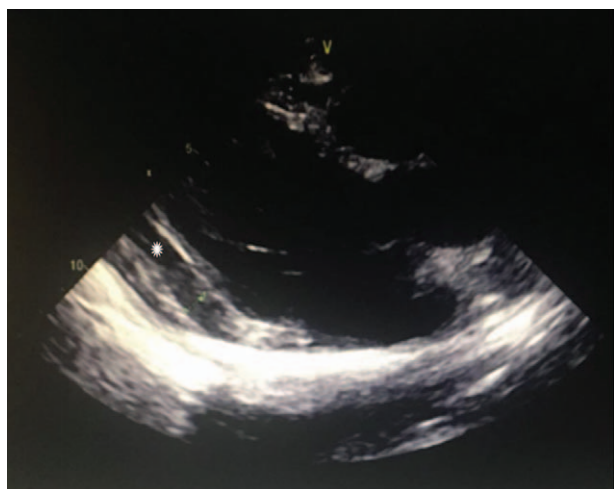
Repeated TTE showing smaller pericardial effusion. The star marker showing pericardial effusion. TTE=transthoracic Doppler echocardiography.
